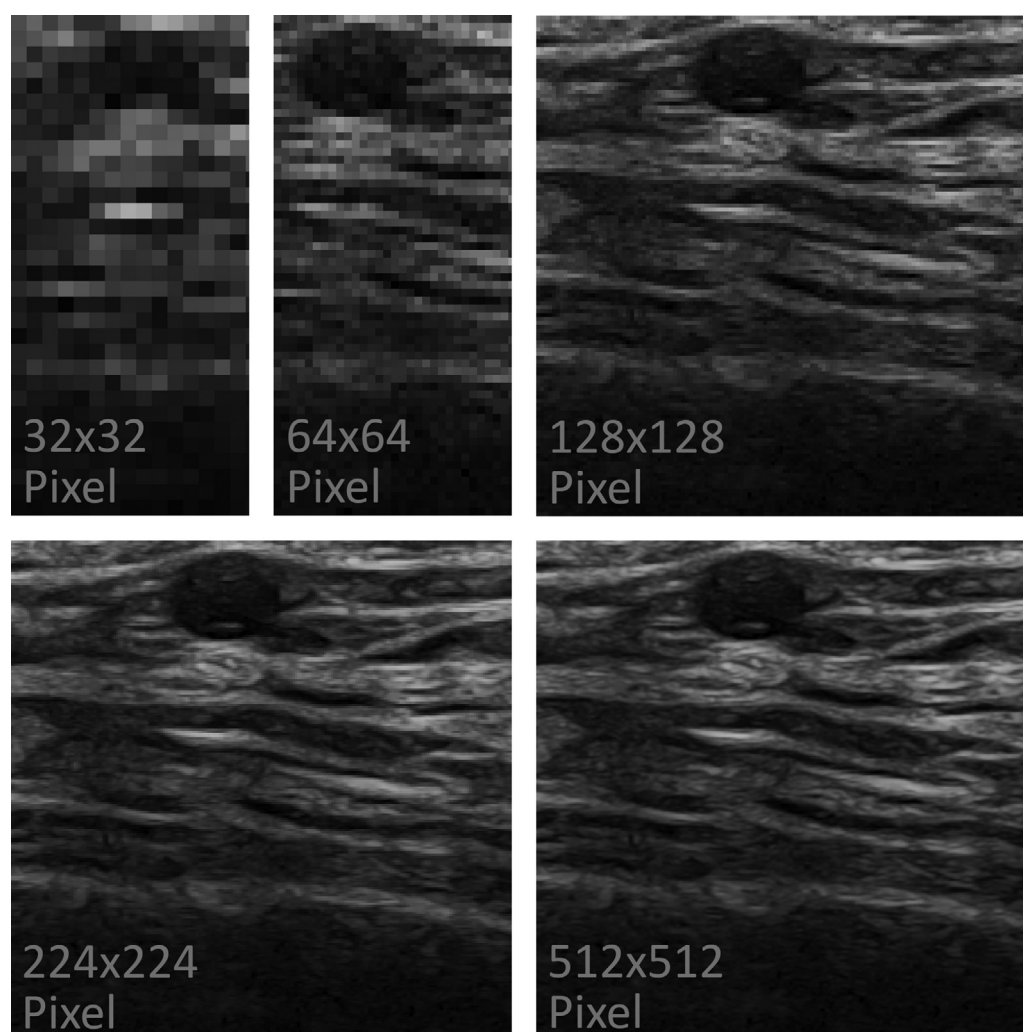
Comparison between the original square 512×512 -pixel cut out from a native B-mode ultrasound image of the superficial common temporal artery in transversal view and its downsized study-specific resolution variants, namely 32×32 , 64×64 , 128×128 , and 224×224 pixels.
